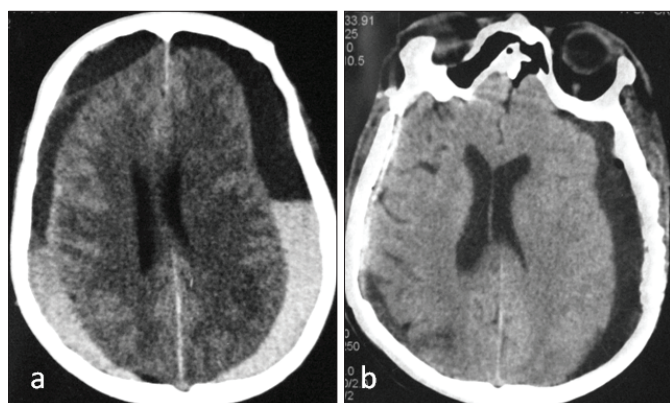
Male, 81, with head trauma caused by fall from the same level. Cerebral CT scan in axial plane highlights: bilateral subdural hematoma (a). Two weeks after surgery it is observed that the collection on the right side disappeared and that a hygroma developed on the left side (b).
